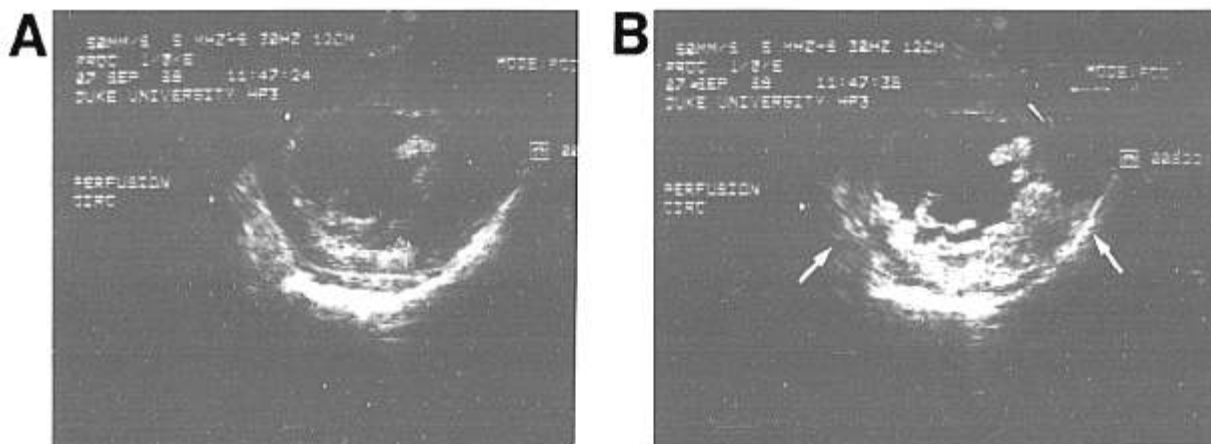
Epicardial short-axis echocardiograph of the left ventricle at the midpapillary level (anterior structures at top). A. During cardiopulmonary bypass immediately prior to contrast injection into a sequential saphenous vein graft to the second and third circumflex marginal coronary arteries. B. Same view at peak contrast intensity after the injection of 2 ml of sonicated Renografin directly into the bypass graft. Perfusion of the entire posterior left ventricle, the posterior septum, and both papillary muscles is clearly visualized (area between white arrows).
